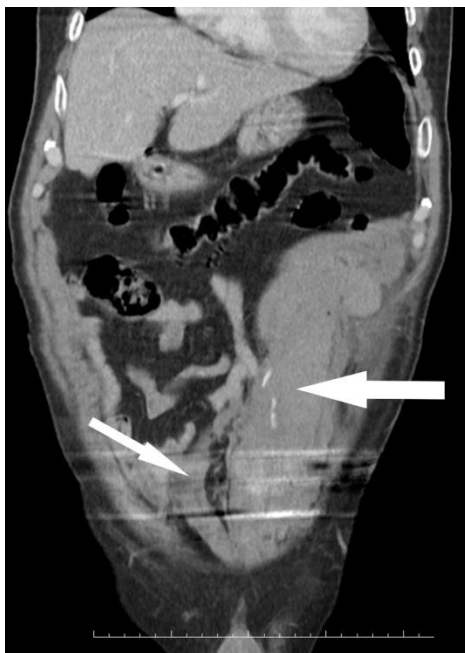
Coronal CT image shows left-sided infra-arcuate line located RSH and contrast extravasation (thick arrow). Right rectus abdominis is in normal size (thin arrow)
